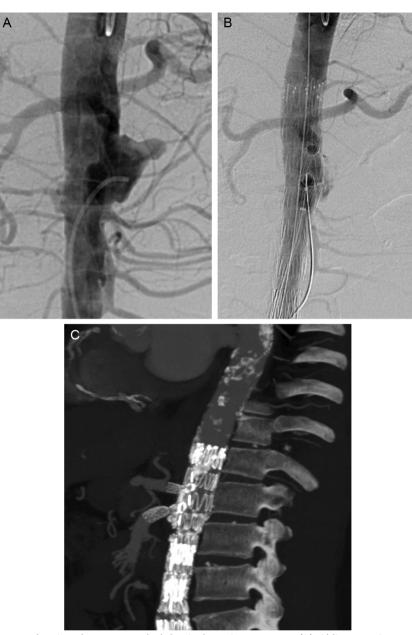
(A) Initial angiogram showing the suprarenal abdominal aortic aneurysm. (B) Oblique angiogram confirming the rotational anatomy of the celiac artery and SMA fenestrations in relation to the deployed stents. (C) Contrast CT with CA and SMA stents in situ (sagittal view).
